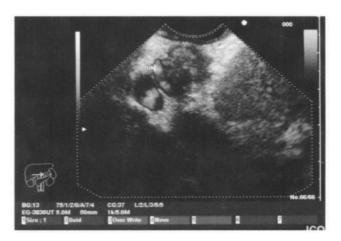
Endosonographic image of a cholangiocarcinoma.
